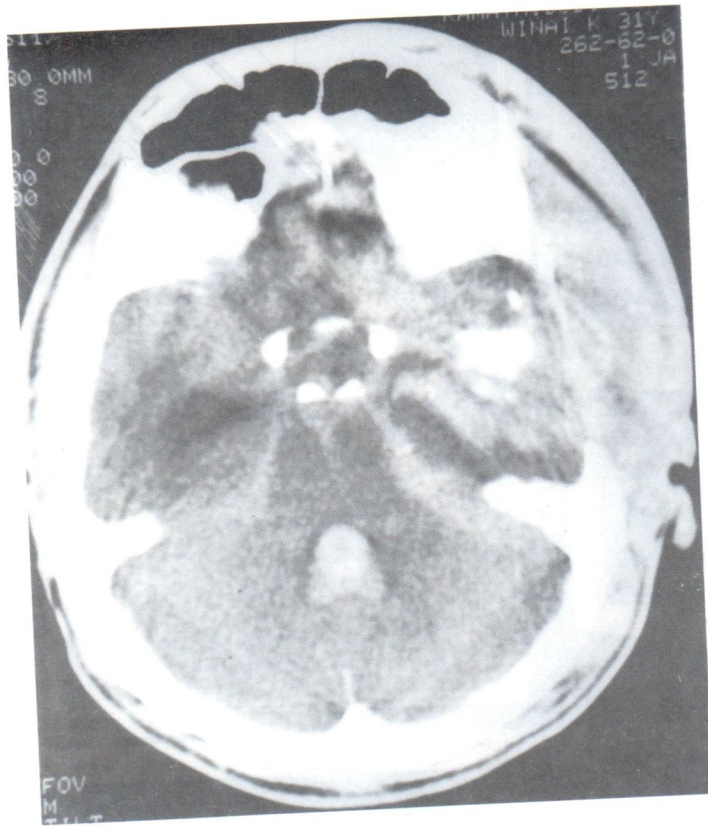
Dense contrast leakage was shown by post angiographic CT scan at left temporal lobe.
